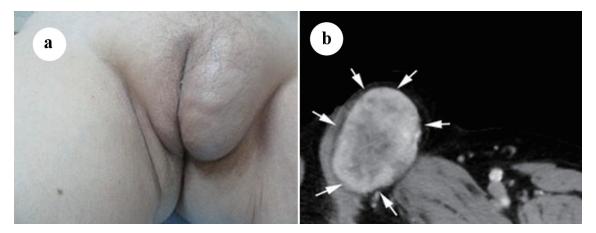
(a) Soft tissue mass on the left labia majora. (b) Axial computed tomography (CT) scan with intravenous contrast showing a mass in the left labia majora with intermediate density and enhancement (arrows).
